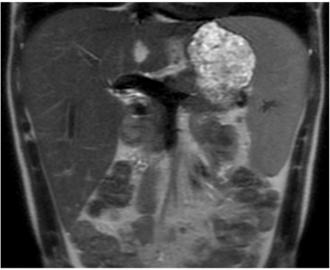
Imaging of the chest and abdomen shows a clear lung nodule (CT, top panel) and presence of hepatosplenomegaly (MRI, bottom panel).
